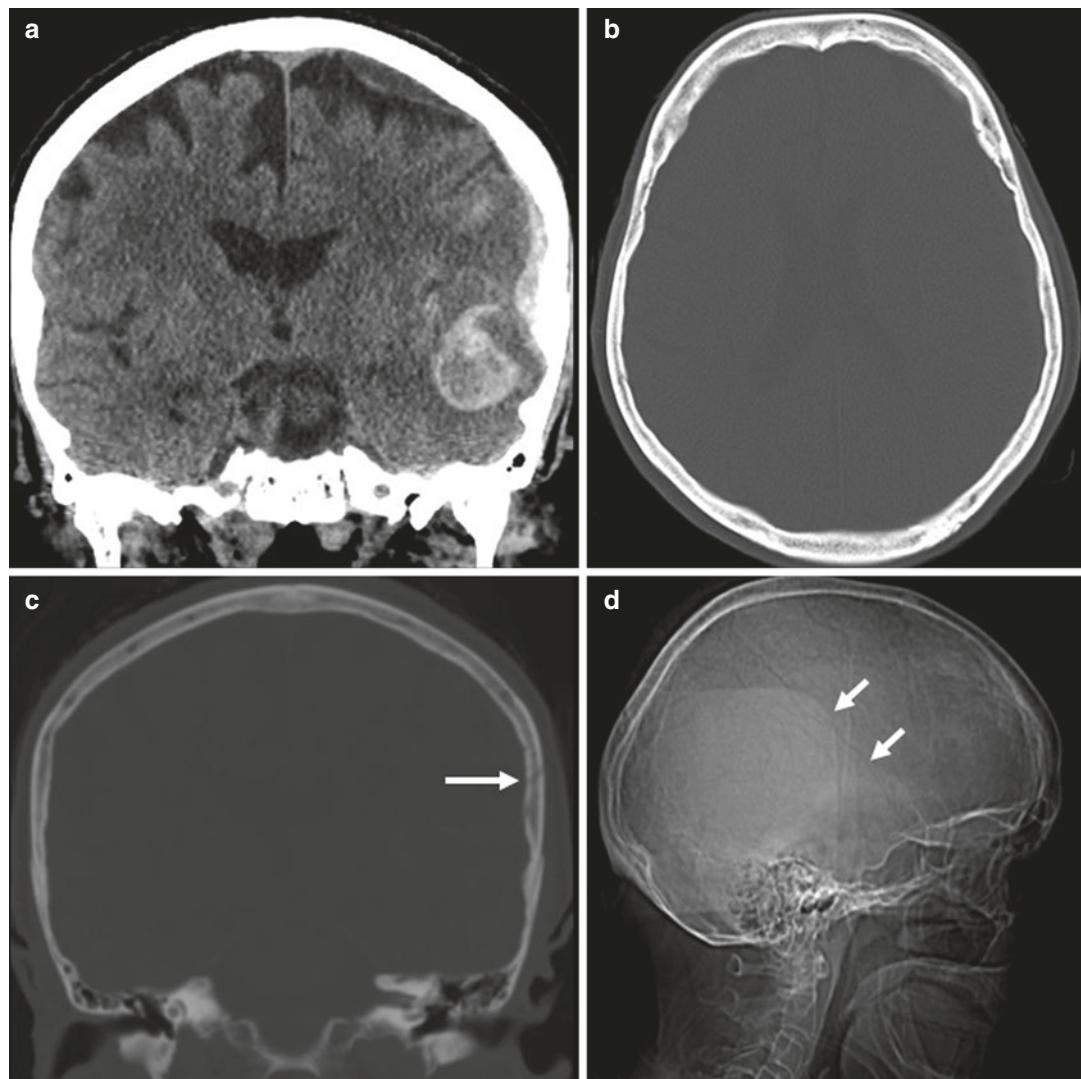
Linear fracture of the squamous portion of the left temporal bone with adjacent post-traumatic intracranial hemorrhage. Coronal CT of the head (a) shows a left temporal hemorrhagic contusion, an acute subdural hematoma, and a small amount of acute subarachnoid hemorrhage. No convincing fracture was seen on the axial CT
